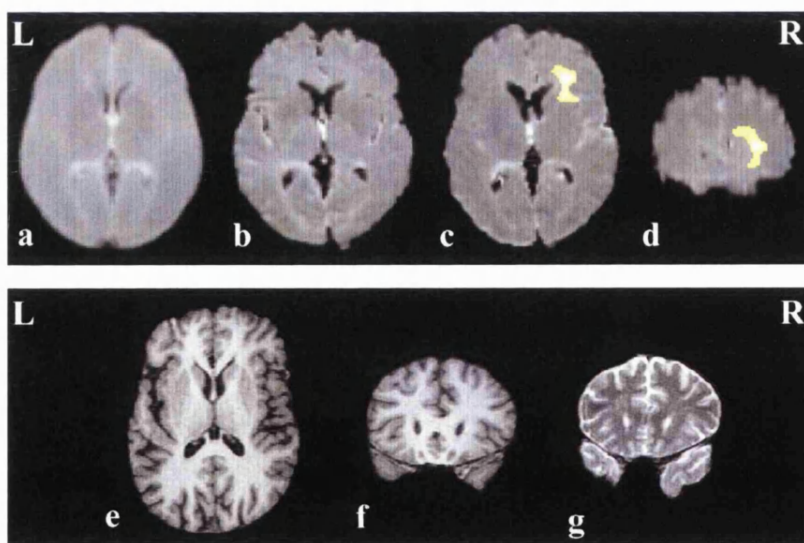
Patient 2. Normalised axial mean diffusivity maps at the same slice position for the averaged 30 control subjects (a) and the patient (b) and (c). Normalised coronal mean diffusivity map (d). The difference in signal to noise between the maps is due to averaging of the 30 controls subjects. The region of significantly increased mean diffusivity is superimposed on maps (c) and (d). The equivalent slices of the patient's T1-weighted axial (e) and coronal (f) and T2-weighted coronal (g) images show no abnormality. The region in (c) was used for quantitative region-of-interest analyses of mean diffusivity values. Note that right on the images is patient's right.
